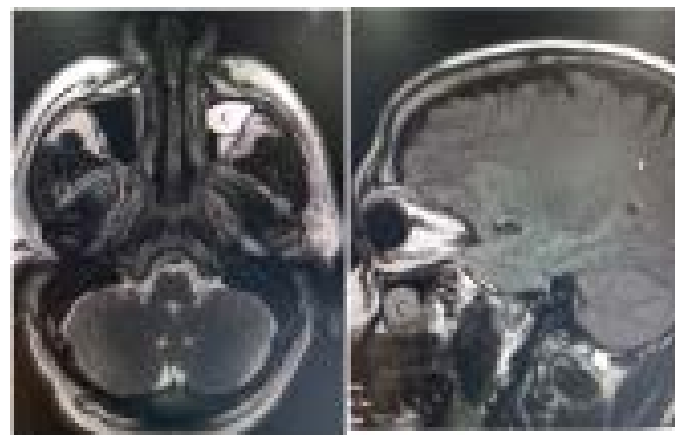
39-year old male patient with vision problem, MRI brain, (a) axial T2WI (b) sagittal T2WI. Both showing a retention cyst (C) in the left maxillary sinus.
